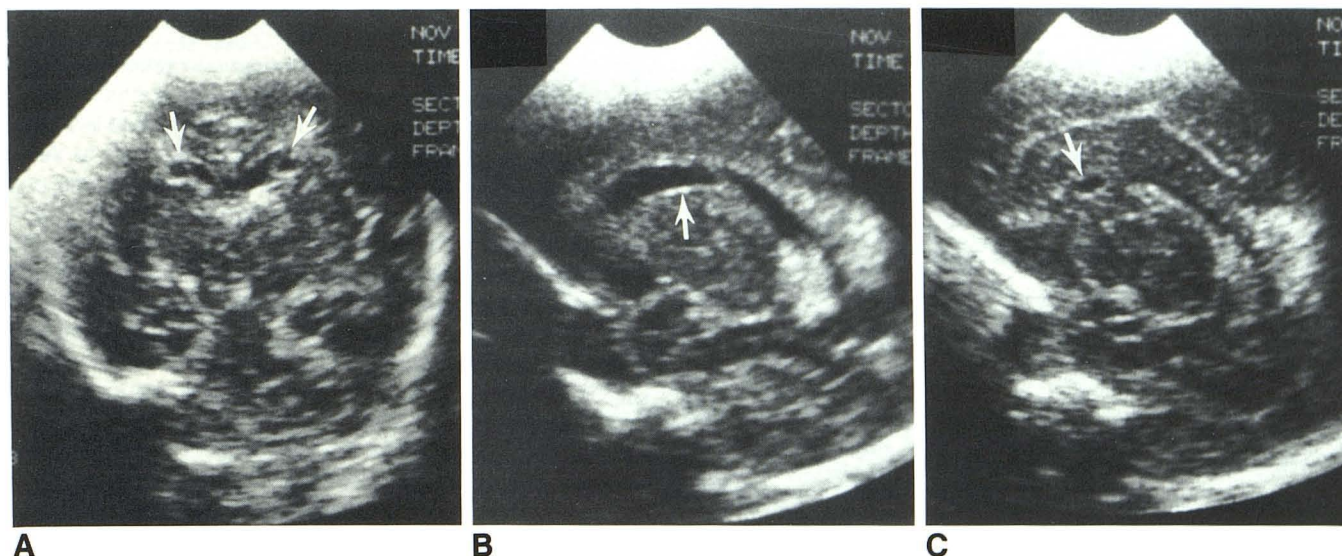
Case 2. Coronal semiaxial (A), left (B) and right (C) parasagittal sonograms show bifrontal periventricular cavitations (arrows).
